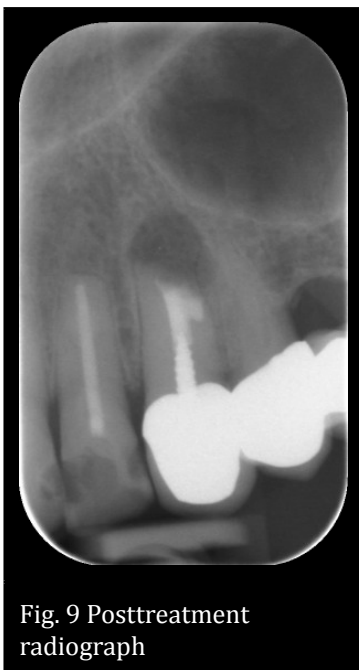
Posttreatment radiograph
